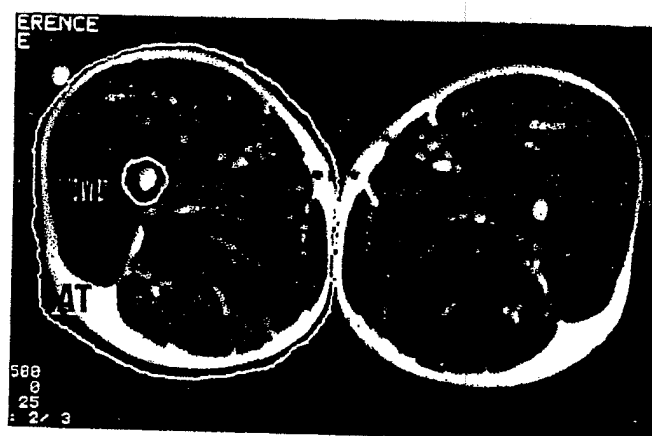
Magnetic resonance imaging: Axial T1-weighted image obtained at midhigh.
